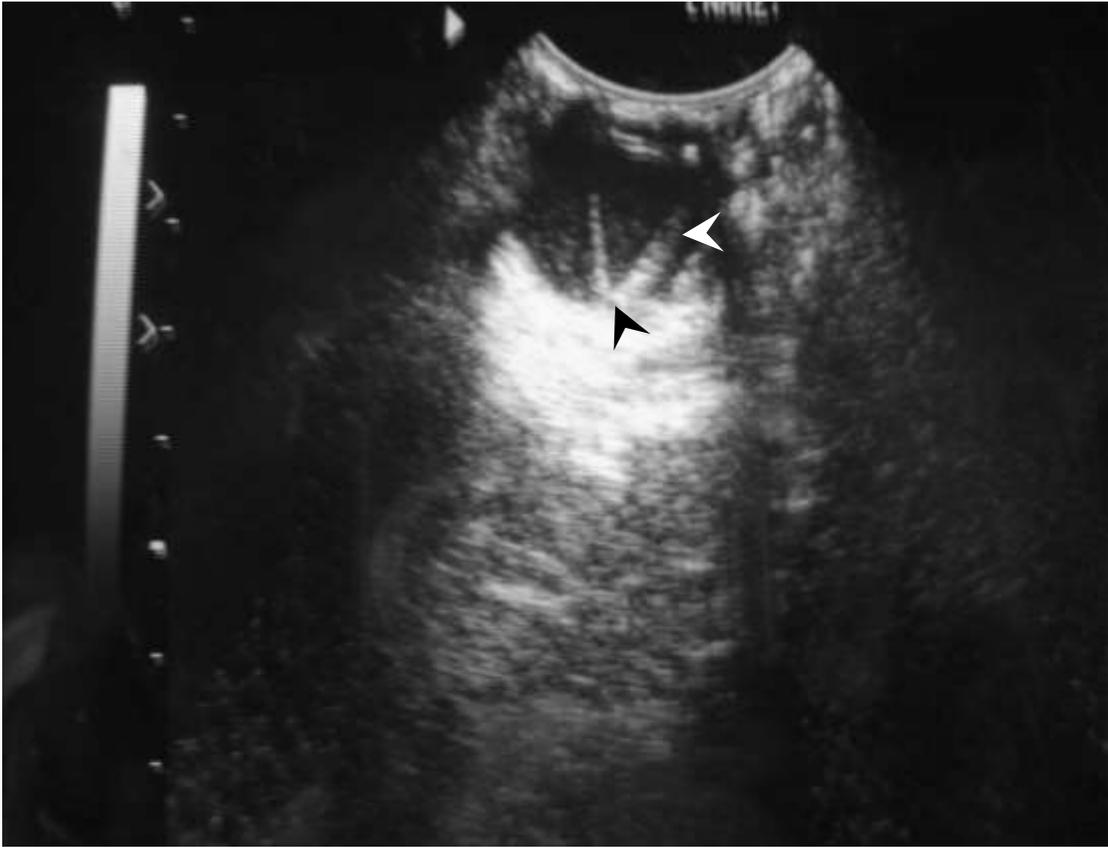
Sonogram of a right eye showing a V-shaped echogenic strands (white arrow head) extending from the ora-serrata anteriorly, with the apex of the V tethered by the optic nerve head (black arrow head).
